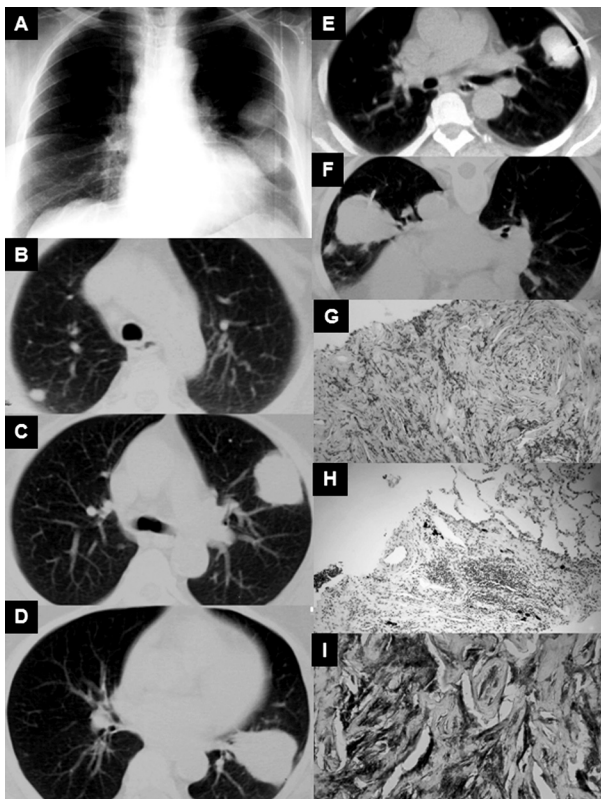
A. Preoperative chest x-ray, showing bilateral lung lesions, one small in the right upper lobe and two larger in the left lung.
